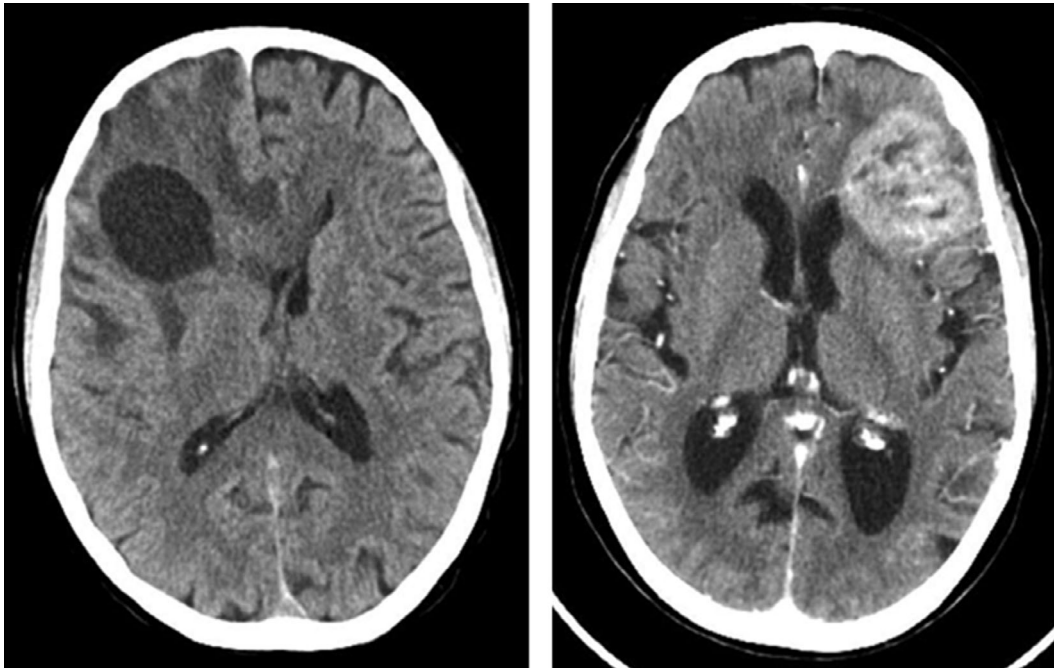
Brain computed tomography scans. Left, patient 1. Right, patient 2.
